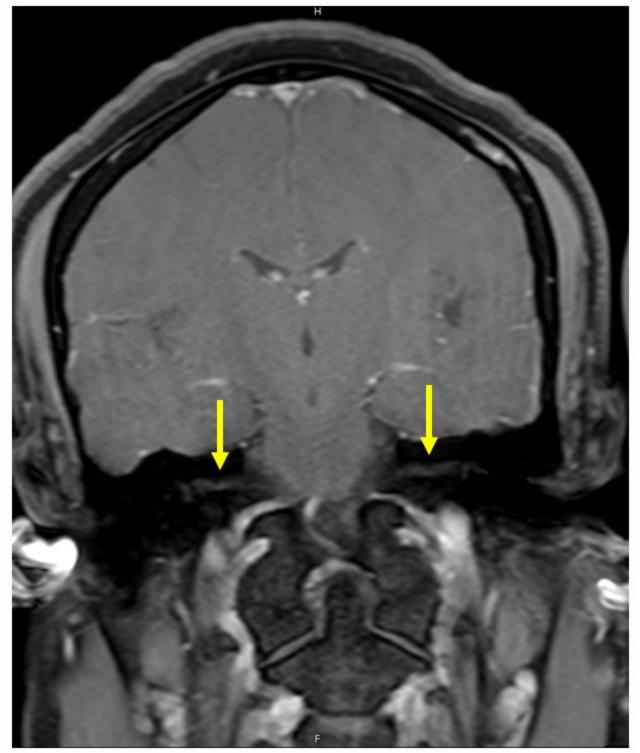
Axial (left) and coronal (right) T1 MRI showing subtle bilateral enhancement along CNVII pathway indicated by yellow arrows. Consistent with an unusual Bell's palsy or other inflammatory changes.
